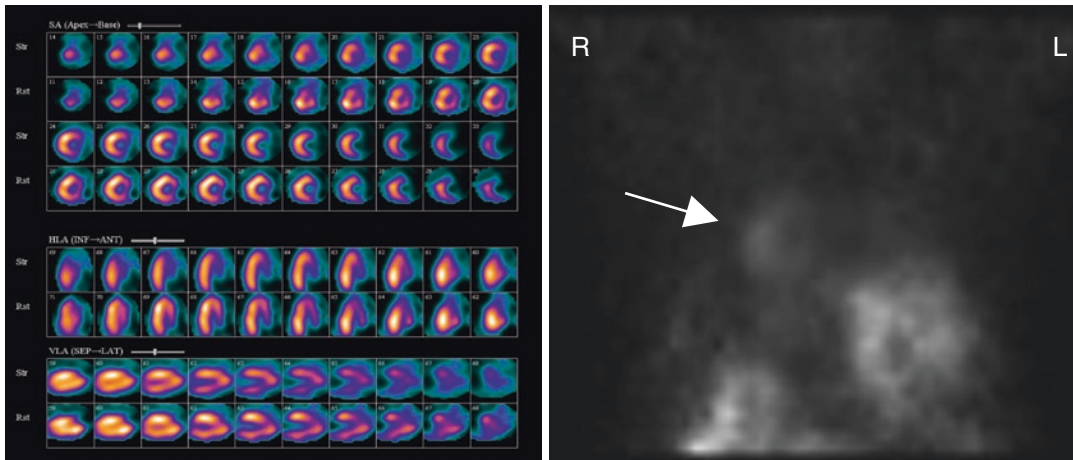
Left panel SPECT images, Right panel: Raw images
